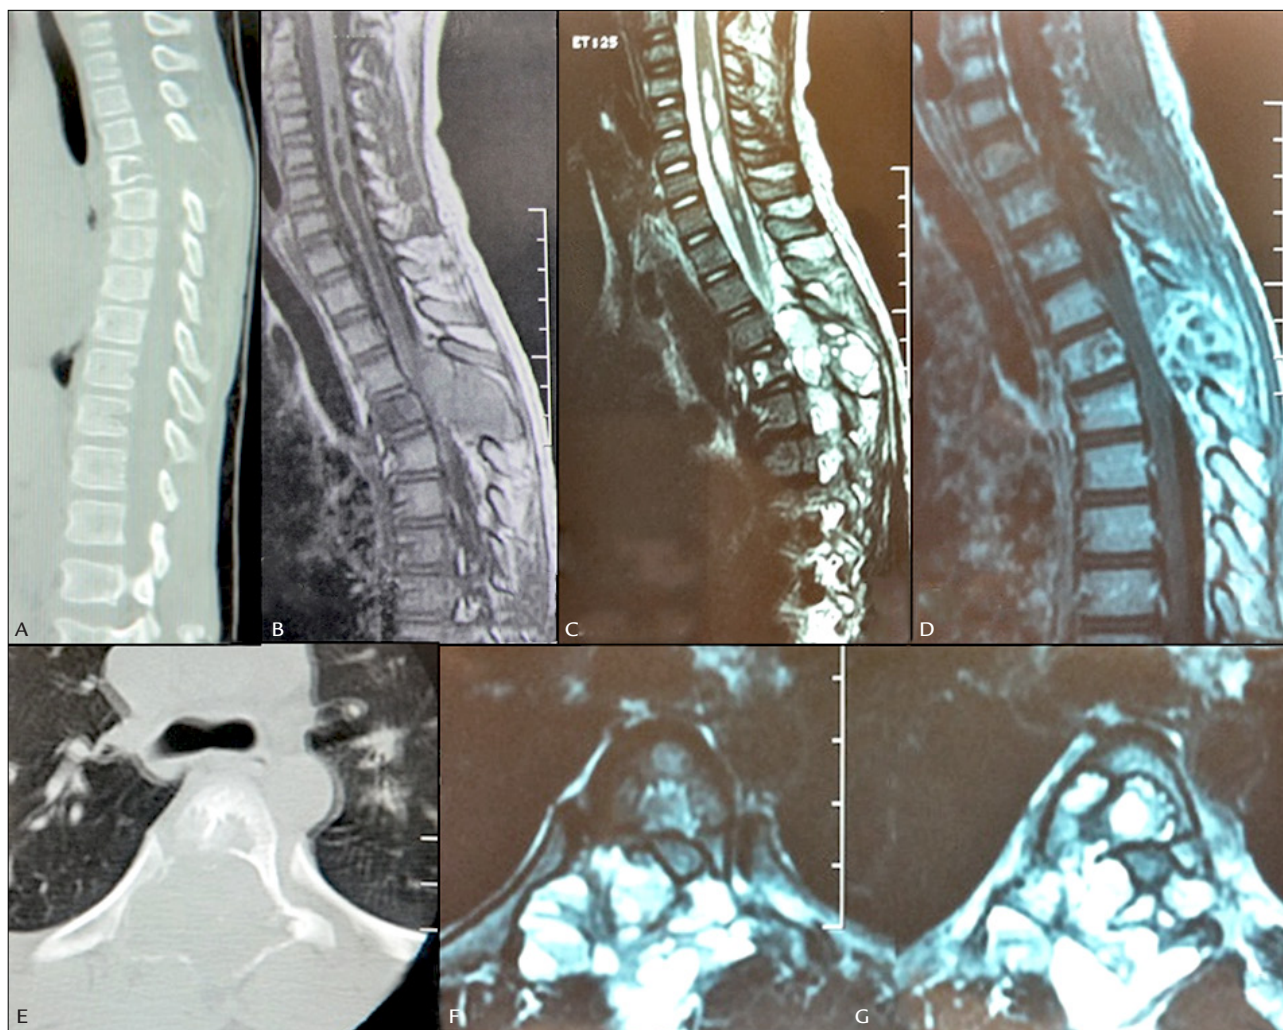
This 5 year-old patient was brought to the emergency department with 2-week progressive leg weakness and thoracic pain. A. Sagittal CT scan with a T5 osteolytic lesion involving the spinous process, pedicles and the posterior vertebral body. B. A Sagittal T1 sequence MRI showing iso signal lesion at the posterior elements of T5 and spinal cord compression. C. Sagittal T2 sequence MRI with a hypersignal heterogeneous lesions and spinal cord compression. D. Sagittal T1 sequence with gadolinium showing irregular enhancement. E. Axial CT scan showing a lytic lesion with insufflation, the same showing in axial T2 sequence, with a heterogeneous insufflation T2 hyper signal lesion with fluid content. The anatomopathological exam confirms an aneurismatic bone cyst.
